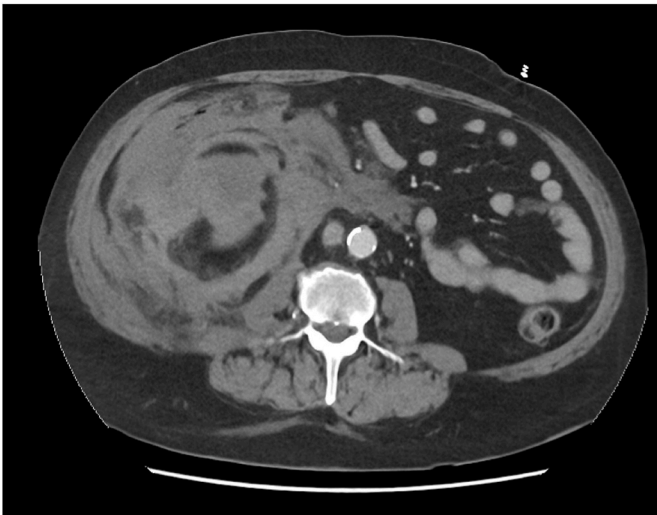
CT AP shows ruptured renal artery secondary to Wegener's granulomatosis.
